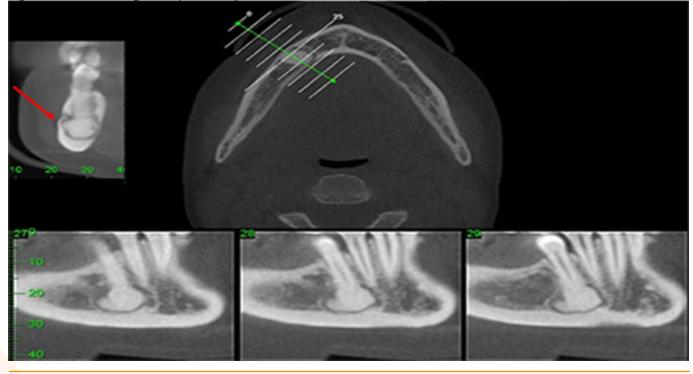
Homogeneous focal cemento-osseous dysplasia at the 45 periapical region. Cortical thinning and expansion adjacent to the lesion is noted (red arrow).
